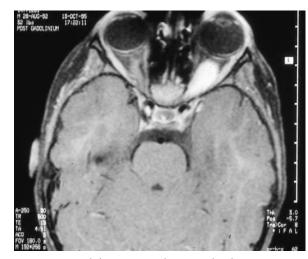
Axial fat-suppressed T1-weighted postcontrast MR scan of the orbit shows a left fusiform enhancing optic nerve mass consistent with an optic nerve glioma.
